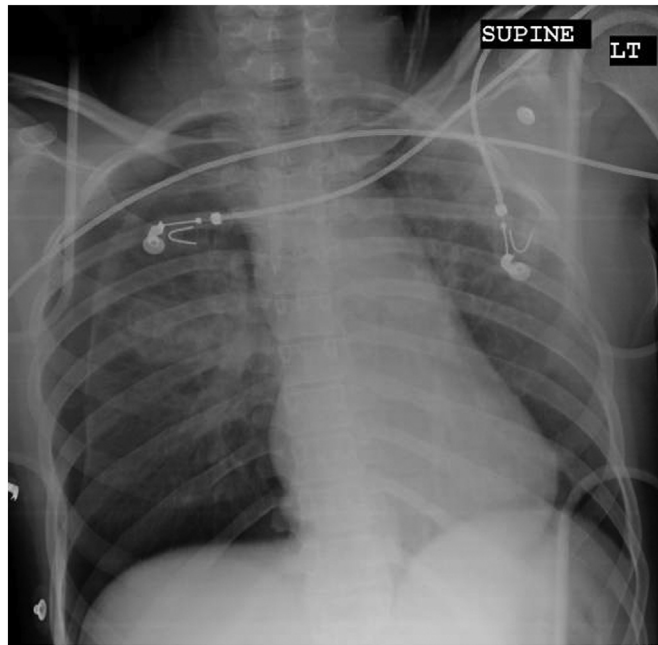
Emergency department chest x-ray revealing right pneumothorax, apical opacities, and loss of aorticopulmonary window.
